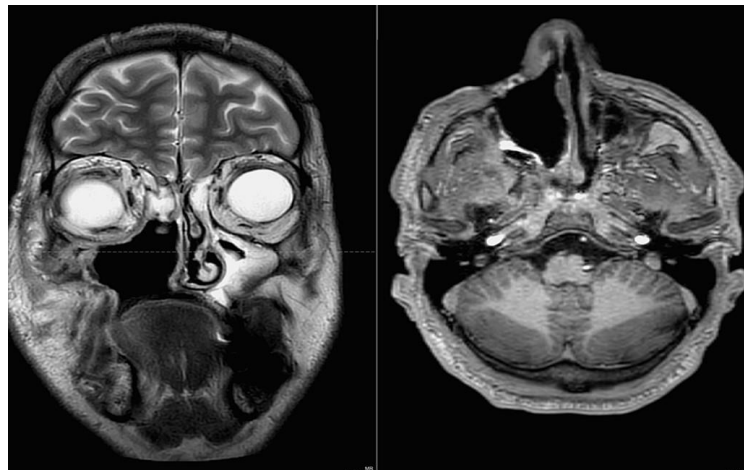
MRI brain for Case 1 (after surgical debridement).
